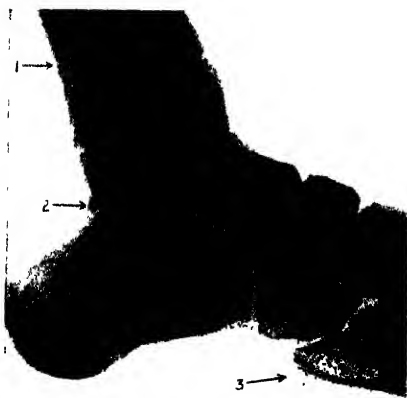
(1) Harris's lines. Two abnormalities are also seen—(2) an os trigonum, and (3) an epiphysis at the base of the fifth metatarsal. These may be of importance as alleged fractures in compensation cases, but an X-ray of the other foot will show a similar condition.
